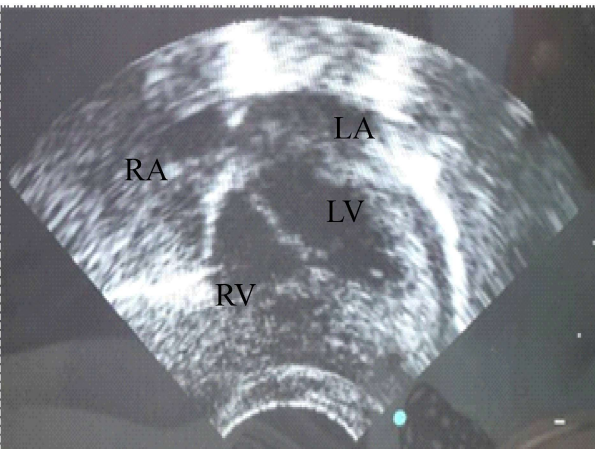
Echocardiographic findings showing resolution of thrombus after treatment
